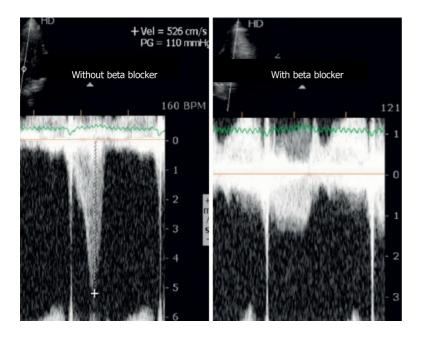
Intraventricular gradient in an athlete assessed before and on beta-blocker therapy. Citation: Cotrim C, João I, Fazendas P, Almeida AR, Lopes L, Stuart B, Cruz I, Caldeira D, Loureiro MJ, Morgado G, Pereira H. Clinical applications of exercise stress echocardiography in the treadmill with upright evaluation during and after exercise. Cardiovasc Ultrasound 2013; 11: 26. [PMID: 23875614 DOI: 10.1186/1476-7120-11-26] Copyright © The Author (s) 2013. Published by BMC part of Springer Nature.
